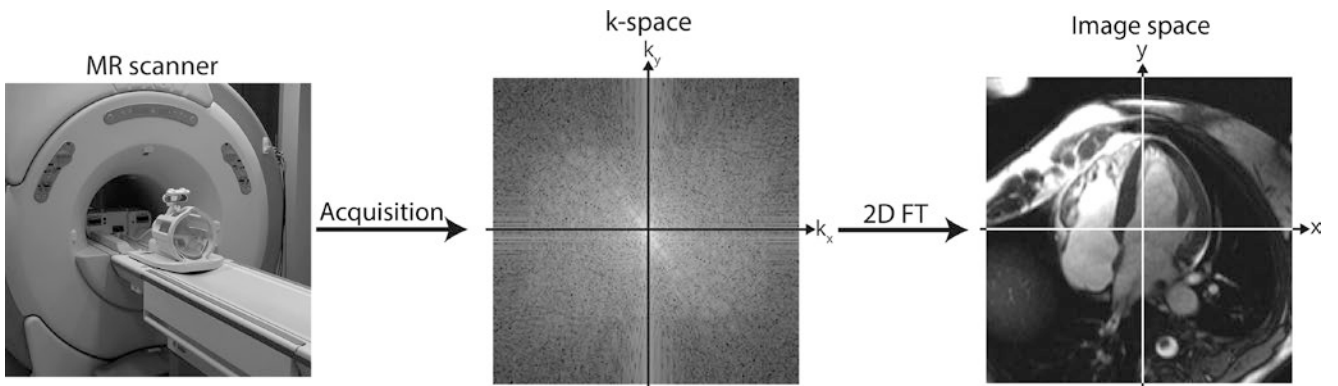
The acquisition and reconstruction process for MR imaging. Data is collected using RF receiver coils. Through the use of time varying gradients, the data are acquired in Fourier space, also commonly
